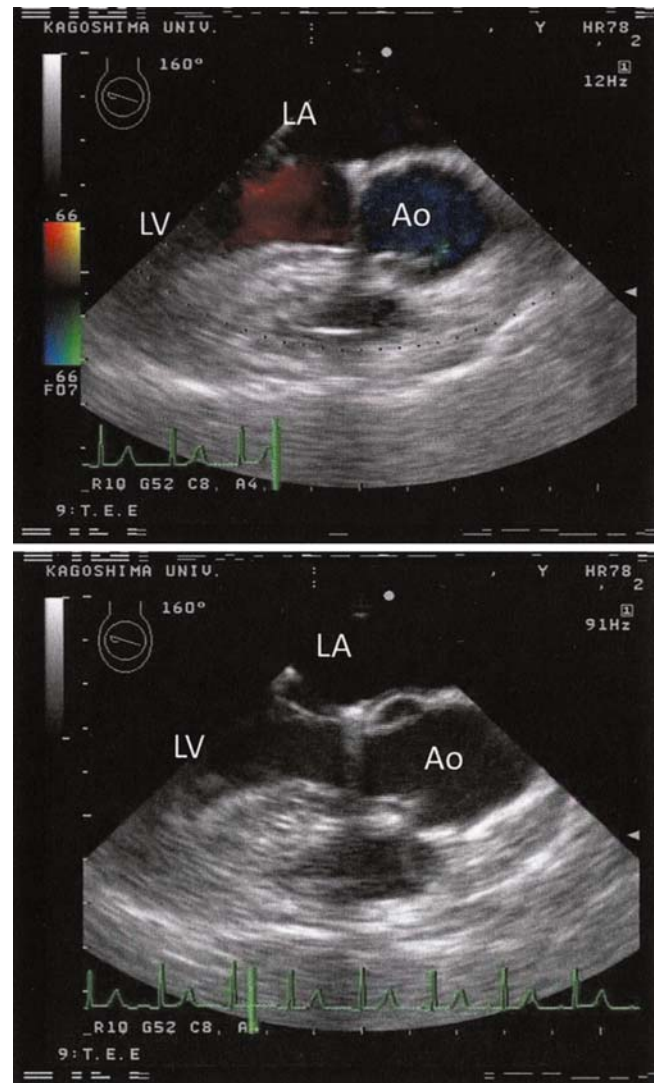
Transesophageal echocardiography mid-esophageal long-axis view after landiolol hydrochloride administration, showing no residual left ventricular outflow tract obstruction or mitral regurgitation. LA, Left atrium; LV, left ventricle; Ao, aorta
